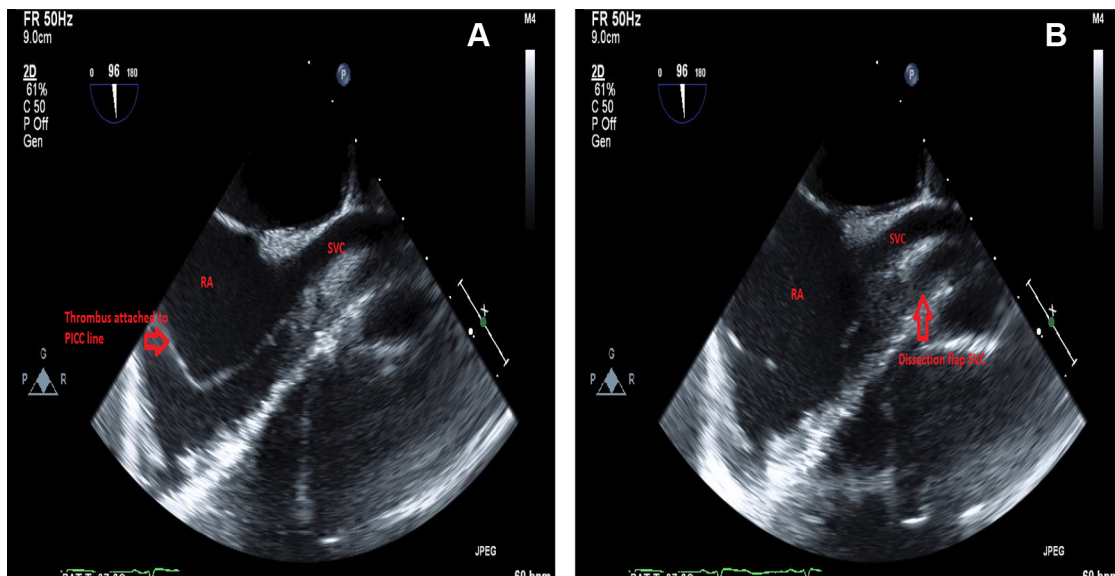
Bicaval view of transesophageal echocardiograph. A, Thrombus attached to peripherally inserted central catheter (PICC) in the right atrium. B, Thrombus attached to PICC line and partial dissection (arrow) of the superior vena cava.
